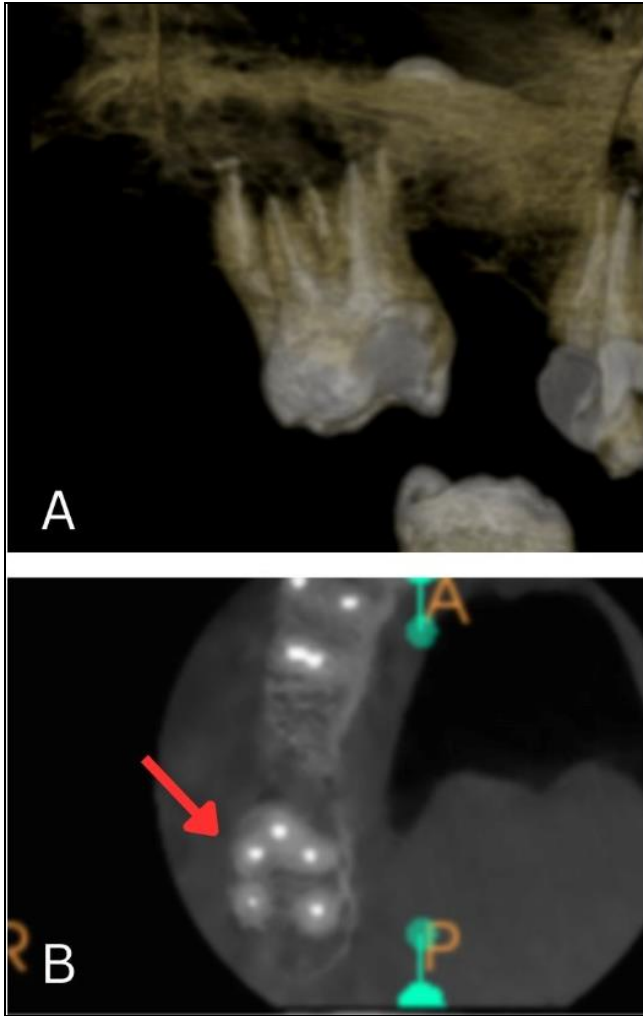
Cone-beam computed tomography (CBCT) images showing five separate roots
